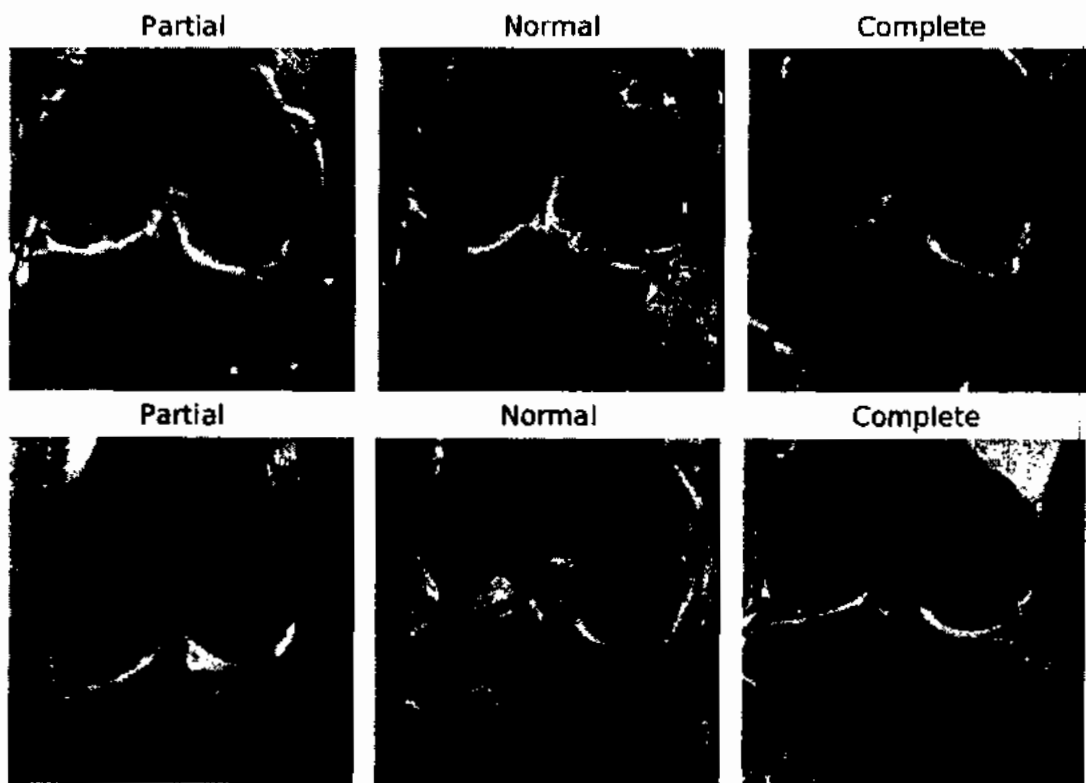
Labeled Knee MR images from Knee MR dataset
